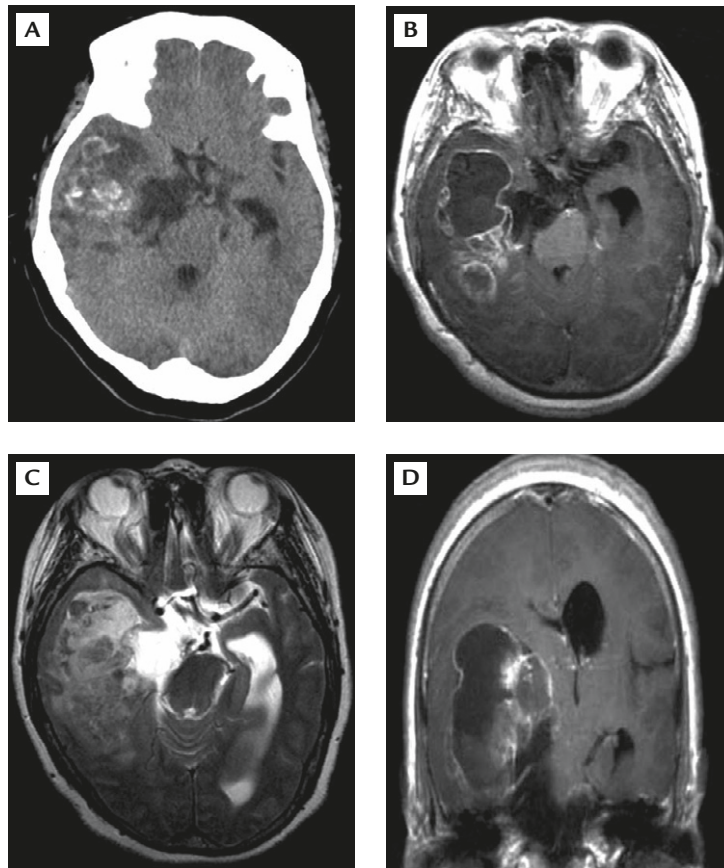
(A) Computed tomography and magnetic resonance imaging showed deteriorated symptoms of patients before surgery, which demonstrated a low-density area in the right cerebellopontine angle and prepontine cistern; an irregular high-density nodular lesion in temporal lobe; and an enlarged ventricle. (B, C, D) Strong enhancement of the wall and irregular nodule in temporal lobe are shown.
